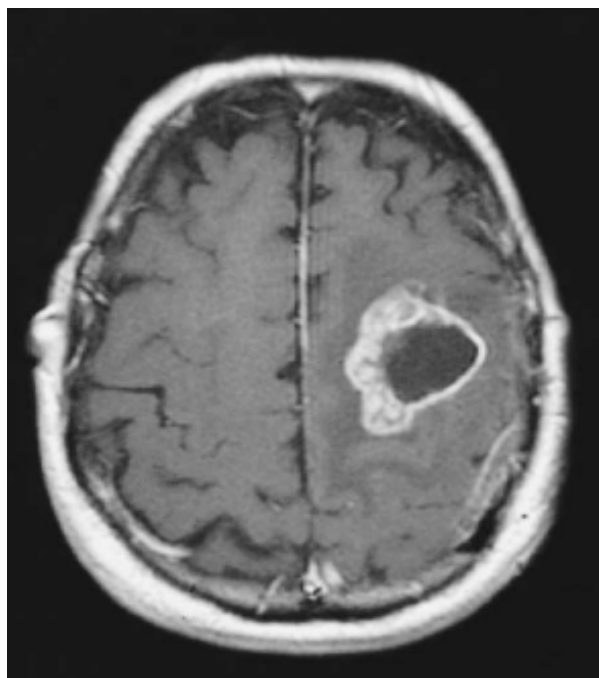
MRI of Glioblastoma Multiforme in the Left Frontal Lobe [12]
